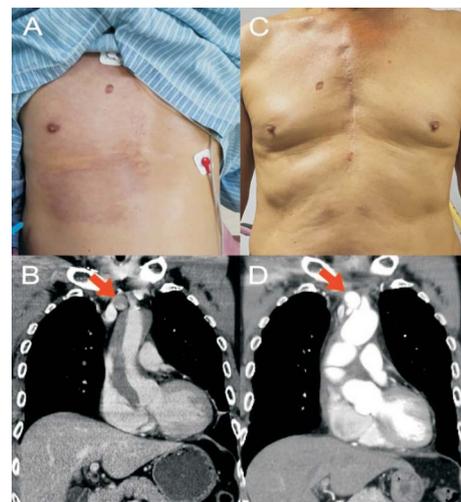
(A) Painless purple skin discoloration over the right anterior chest wall. (B) Computed tomography reveals a type A aortic dissection involving the brachiocephalic artery, resulting in the true lumen appearing as a slit-like channel at its origin (arrow). (C) The normal appearance of the chest wall at the 2-year follow-up visit. (D) Follow-up CT reveals good contrast enhancement of brachiocephalic artery (arrow).
